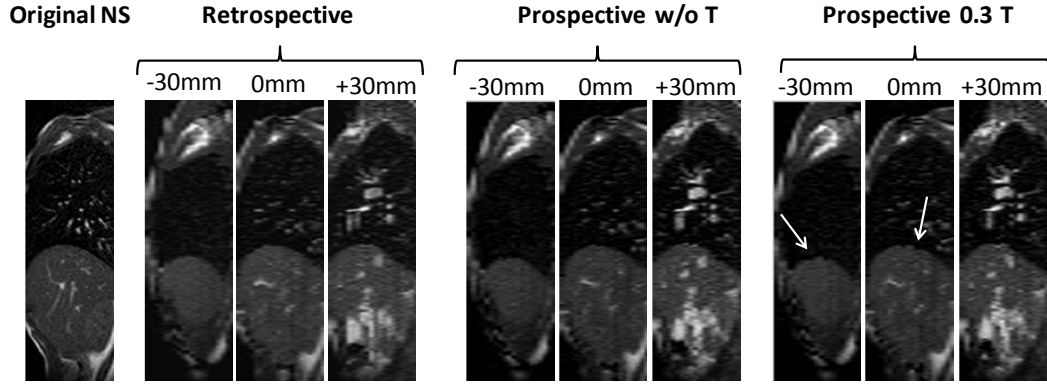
6. Extraction of sagittal cuts from reconstructed 4D-MRI. The distances of the extracted sagittal cuts are 30mm on the left side and 30mm on the right side of original NS position.
